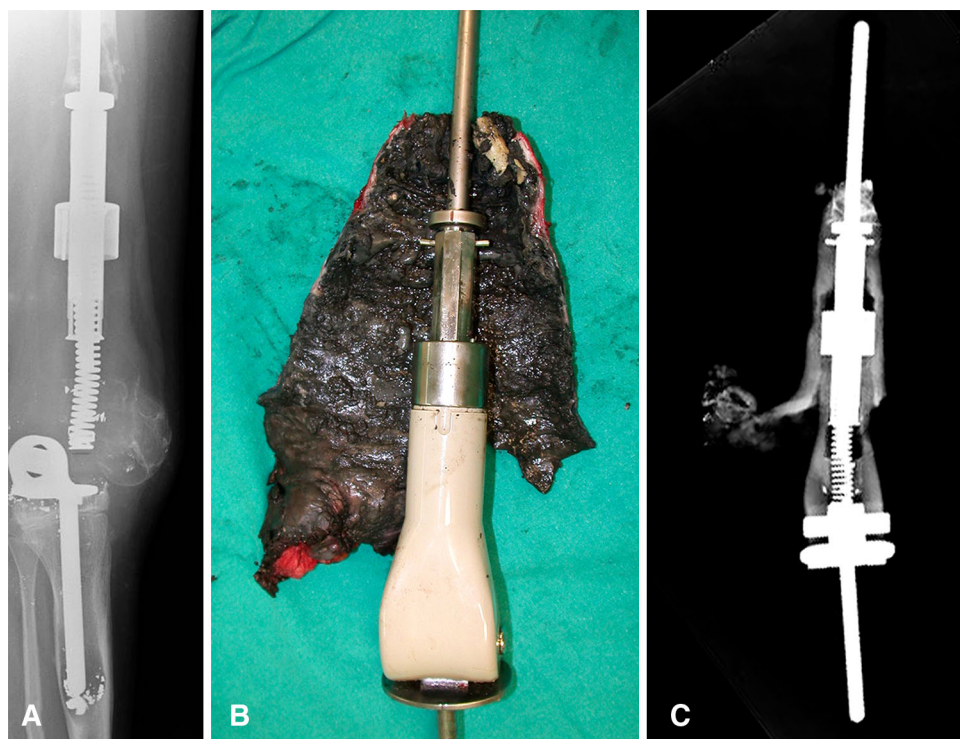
C (A) The radiograph shows signs of implant failure including metallic debris in the soft tissues and breakage of the spring. (B) The explanted prosthesis shows the periprosthetic
